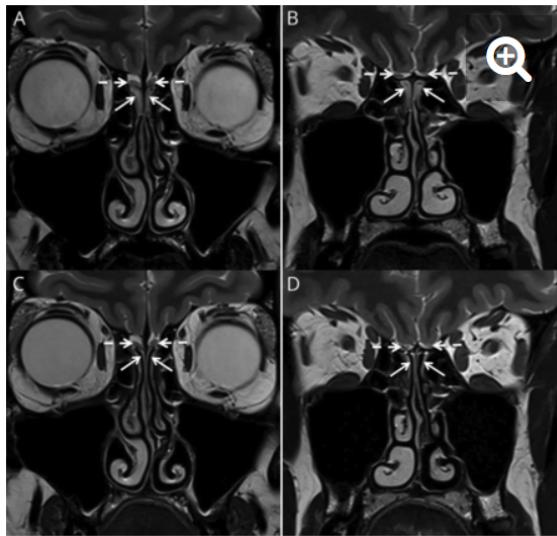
Patient 11: 38-year-old woman with severe acute respiratory syndrome coronavirus 2 infection. Coronal section of the olfactory clefts (OC) and bulbs on MRI on 2D T2-weighted sequences. (A and B) On the first MRI, the olfactory bulbs (white dotted arrow) are normal (right 38.1 mm³, left 42.1 mm³), while a bilateral inflammatory obstruction (white arrow) of the OC is observed below the olfactory bulbs (A, white dotted arrow) and olfactory tracts (B, white dotted arrow). (C and D) At the 1-month follow-up, the volume of the olfactory bulbs (white dotted arrow) remains normal (right 29.2 mm³, left 39.3 mm³), and no inflammatory obstruction of the OC is observed within the (A) anterior and (B) posterior parts of the OC. The olfactory score at the first consultation and the 1-month follow-up was 0 and 10, respectively.
